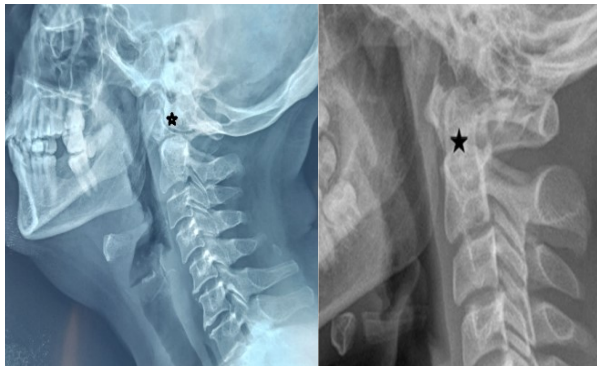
Lateral radiograph of OO. Left, a corticated ossicle is located dorsal and superior to the anterior arch of C1 consistent with an ectopically located os (star). Right, Normal comparison radiograph demonstrating the normal morphology of the odontoid process (star) and A-a distance.
